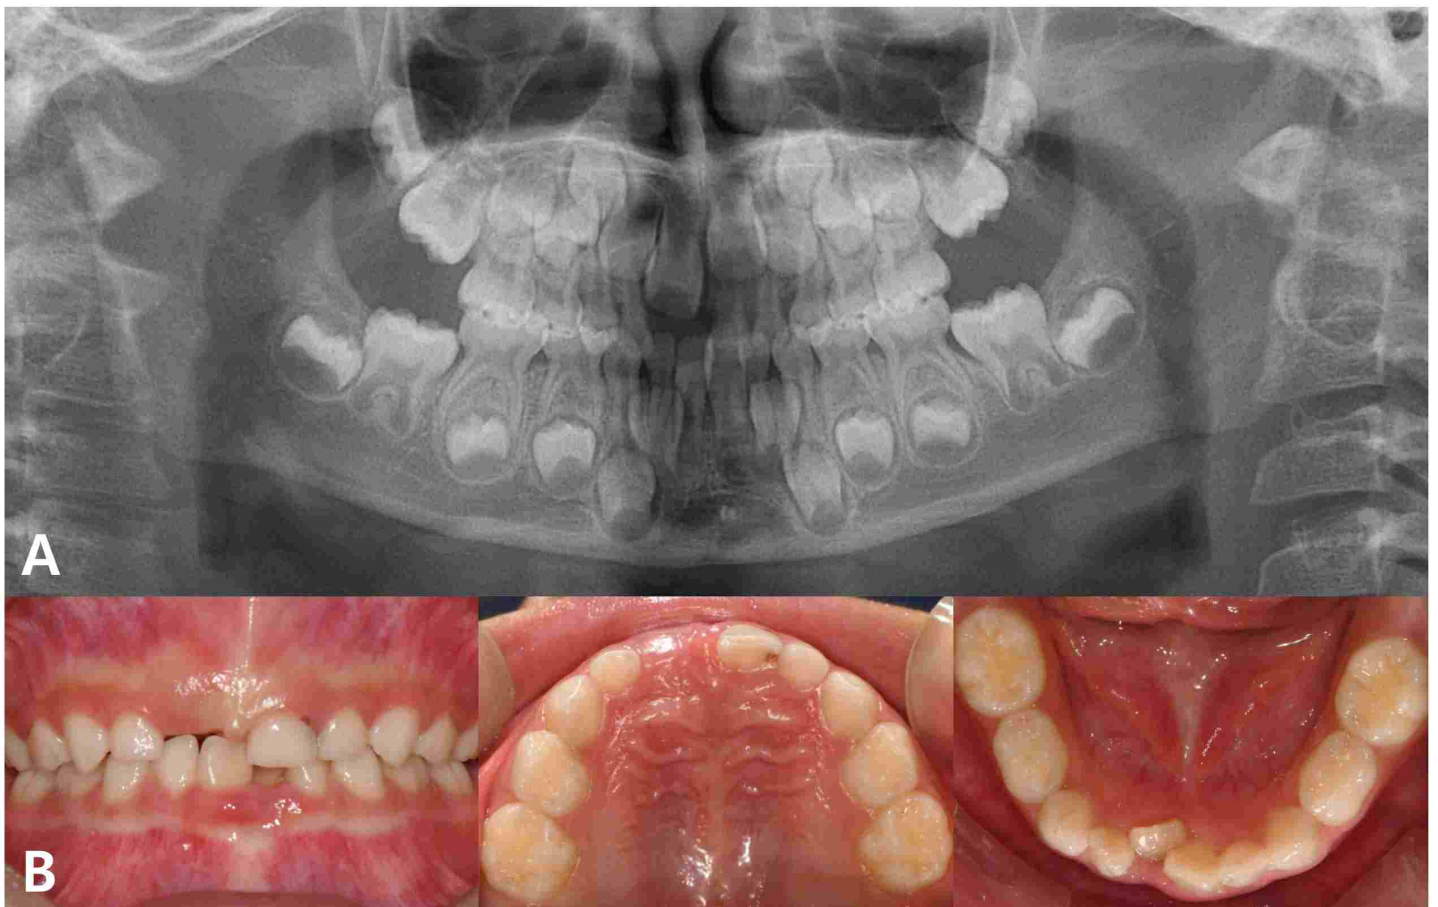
Image captured 14 months after teeth extraction. (A) Panoramic radiograph. (B) Intraoral photo. Tooth #41 was labioversed and tooth #31 erupted well.
